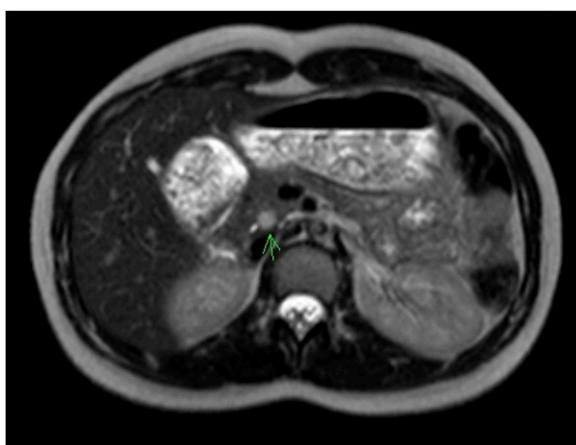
T2-Weighted axial magnetic resonance image of the abdomen showing a lesion (green arrow) at the head of the pancreas.
